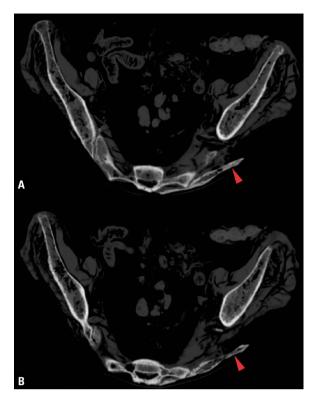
Axial CT images through pelvis; A. Level of S3 vertebra; B. Level of S4 vertebra; red arrowheads — sacral "ribs".
